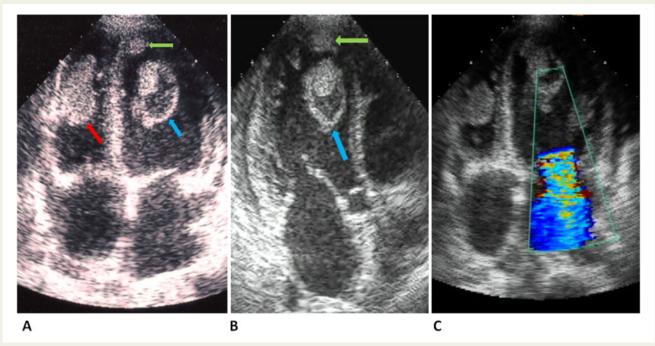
Transthoracic echocardiography apical views showing (A) biventricular apical thrombi (right ventricle, red arrow, A; left ventricle, green arrow, A and B) and a vacualated mid-septal left ventricular thrombus (blue arrow, A and B). Colour-Doppler (C) showing secondary severe mitral regurgitation.
